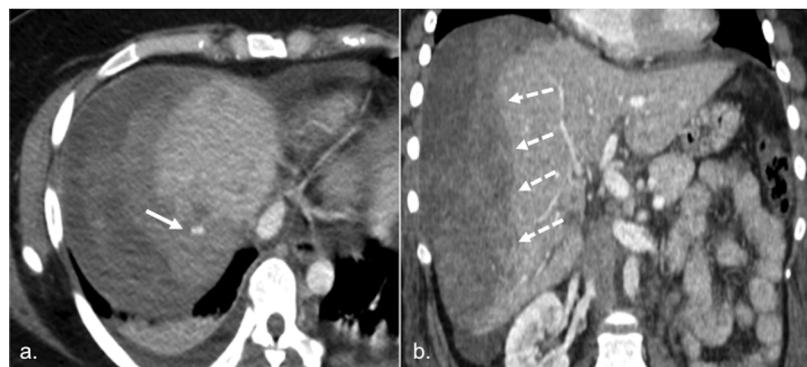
Hepatic rupture in a 28-year-old woman who developed acute abdominal pain on the first day following an emergency Caesarian birth in a context of pre-eclampsia. CT shows a large subcapsular haematoma (b, dotted arrows) with foci of active bleeding (a, arrow).
